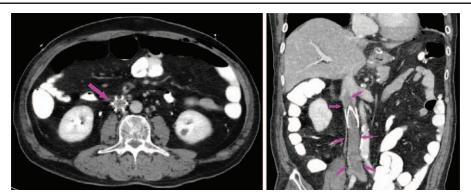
On the cross-sectional and coronal CT image, the purple arrows indicate a massive thrombus in the IVC occupying an intravenous space from approximately 2 cm proximal to the IVC filter to the left common iliac vein. CT = computed tomography, IVC = inferior vena cava.
